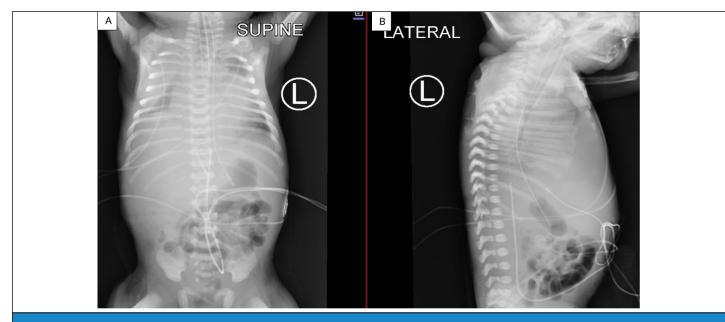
Chest and abdominal X-rays Anteroposterior and lateral views. A: Anteroposterior view showing moderate to large right pleural effusion, UVC pushed down to T9-10 vertebral level, UAV at T10 vertebral level, enlarged cardiac shilloutte, orogastric tube in the distal stomach and an endotracheal tube at T2-T3 vertebral level. B: Lateral X-ray showing UVC tip pushed below the diaphgram giving an impression to be in the liver.
